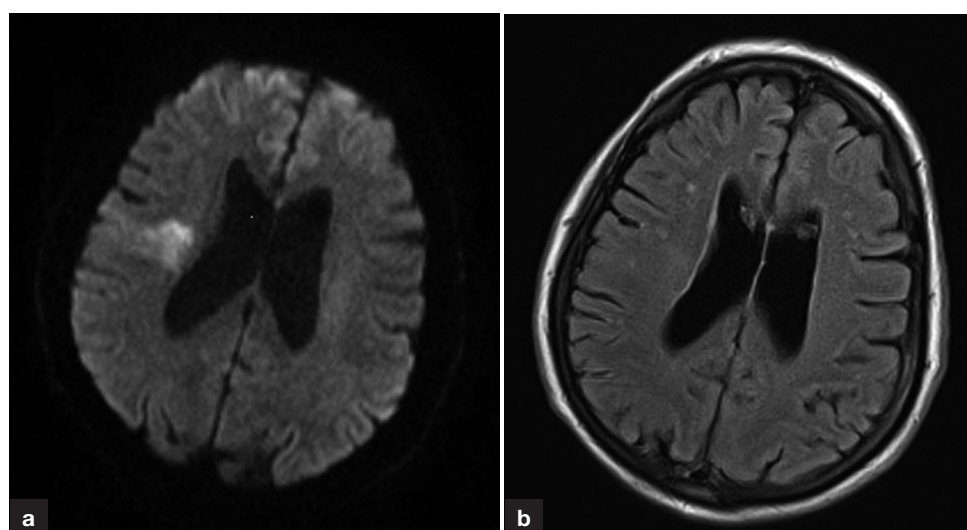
Magnetic resonance imaging diffusion weighted imaging/fluid attenuation inversion recovery mismatch in ischaemic stroke of unknown onset. The patient was last known well at 10:00, found at 15:00, magnetic resonance imaging scan 17:25, thrombolysed at 17:40. a. Diffusion weighted imaging lesion involving right corona radiata and extending into posterior insula without (b) corresponding fluid attenuation inversion recovery lesion.
